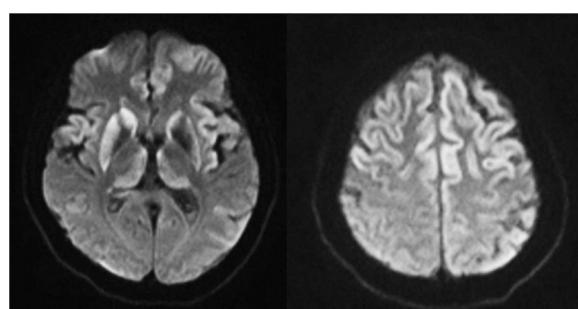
DWI sequences with restriction of the frontal and insular cortex, putamen and caudate (predominantly right asymmetry) and thalamus (mediodorsal nucleus).
